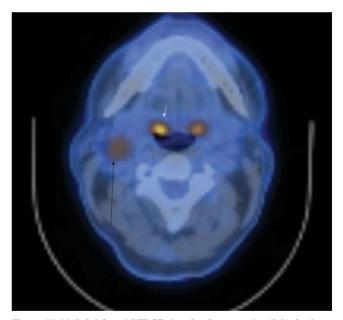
Axial-fused PET-CT showing increased activity in the right tongue base (white arrow) in a patient presenting with a right sided neck mass (black arrow) and no apparent primary on clinical examination or conventional CT. Note the normal physiological activity in the left tongue base.
